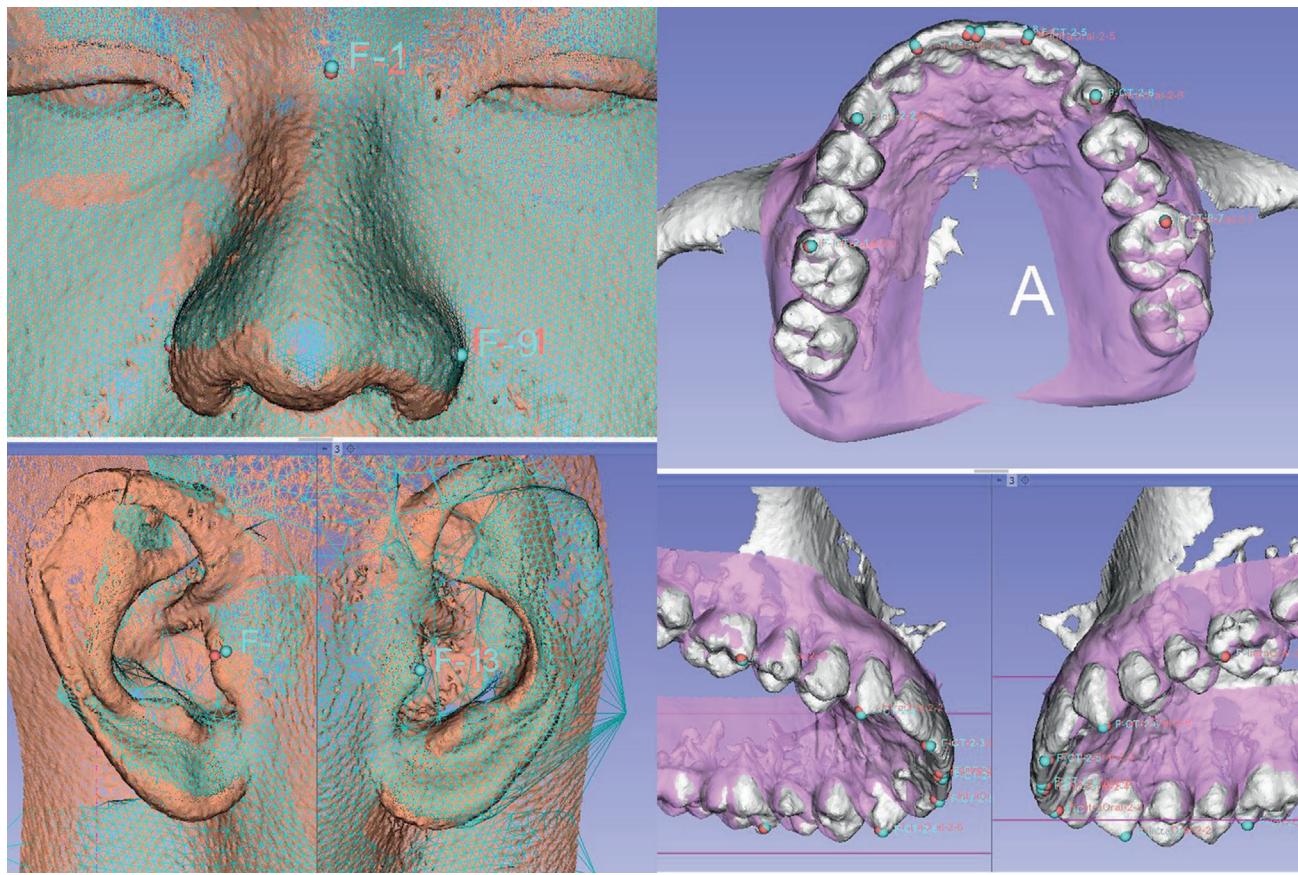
Error measurement with facial and dental landmarks comparison: red, landmarks from cone beam computed tomography; blue, landmarks from intraoral scan/stereophotogrammetry.
